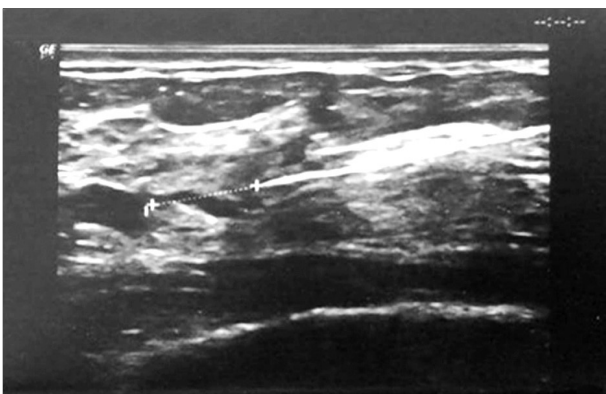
Ultrasound guided injection of charcoal at the superficial margin of suspicious lesion BIRADS 4a measured 5.5X4 mm in patient aged 36 years with positive family history of breast cancer. Postoperative pathology revealed fibroadenosis
